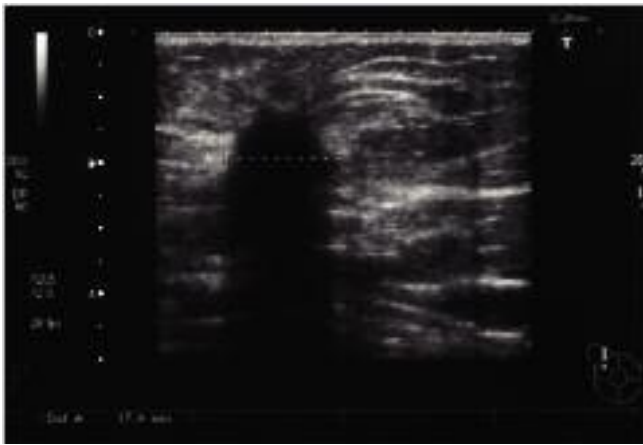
Ultrasound image showing an irregular hypoechoic mass, taller than long, crossing tissue planes, with distal acoustic shadowing typical for carcinoma.
